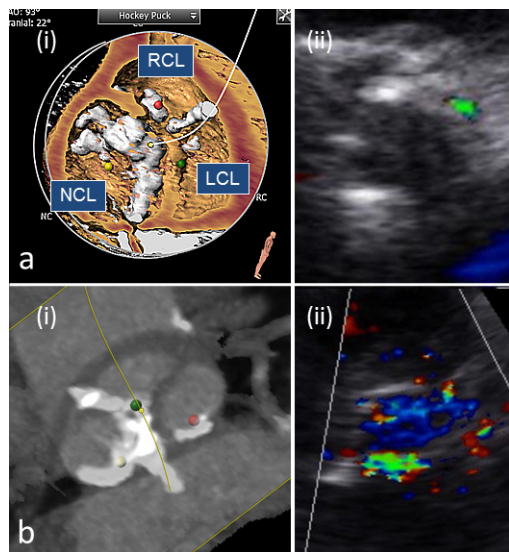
Impact of calcium burden on paravalvular leaks in a case of asymmetry (a) and LVOT calcium (b), (i) volume rendering (VR) shows asymmetric calcium distribution with case A, and additional LVOT calcium below the non-coronary leaflet with case B, (ii) post-implantation transesophageal echocardiography.
